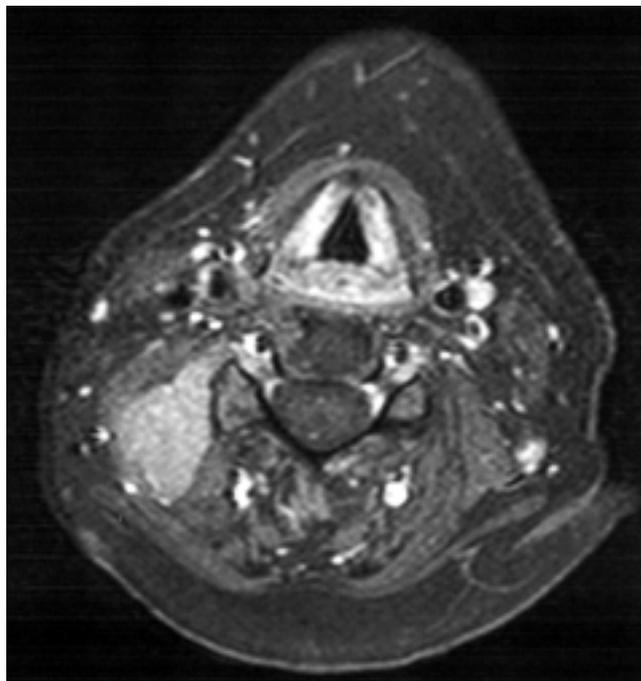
T1 axial post-gadolinium magnetic resonance image shows a mass that appears to be insinuating into several intravertebral foramina, but not occluding them.
